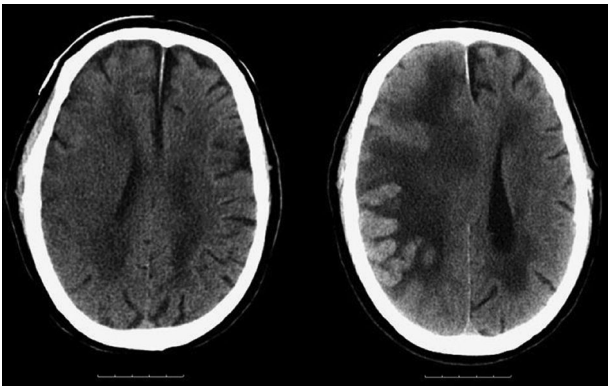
Haemorrhagic transformation on CT. A pair of images show haemorrhagic transformation into a large infarct. The left-hand scan is in the first 24 hours. At this time no haemorrhage is present. The scan on the right is after a few days. © Anthony Pereira.
